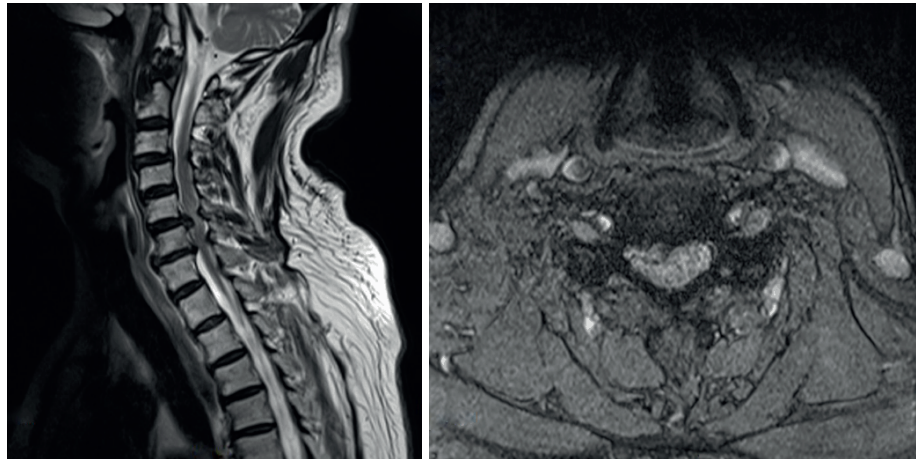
Emergent T2 weighted sagittal and axial cervical magnetic resonance images taken immediately after lumbar surgery reveal severe cervical cord stenosis with cord compression and high signal intensity suggesting cord injury at C5-6 and C6-7.
